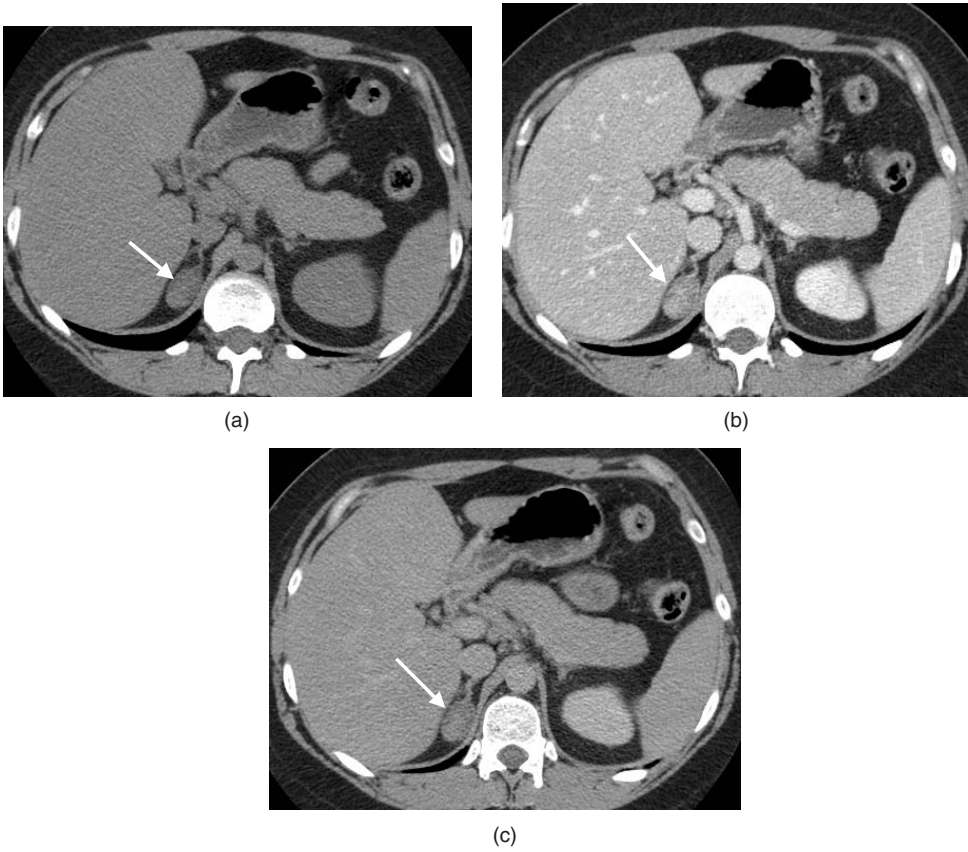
Lipid-poor adenoma. Axial unenhanced CT shows a right adrenal mass measuring 27 HU (arrow) (a). Following intravenous contrast enhancement the mass measures 96 HU (arrow) (b) and 50 HU (arrow) on delayed images (c), respectively. This mass had an absolute enhancement washout of 67%. Absolute Washout = $96 - 50 / 96 - 27 \times 100 = 67\%$.
